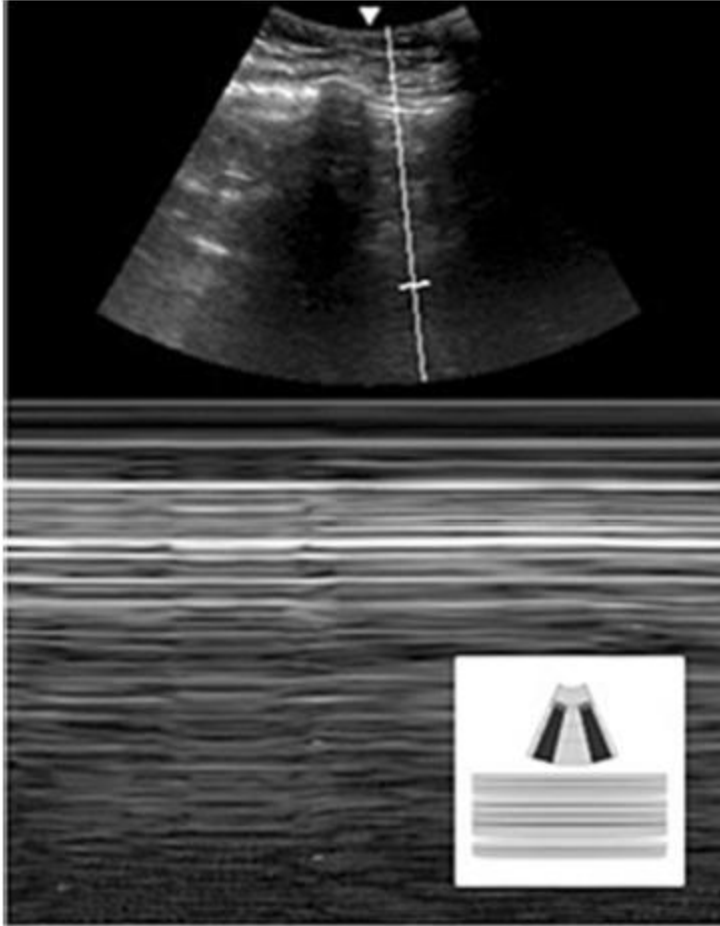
Ultrasound image of abnormal lung presentation with the absence of lung sliding (M-mode): barcode sign.
